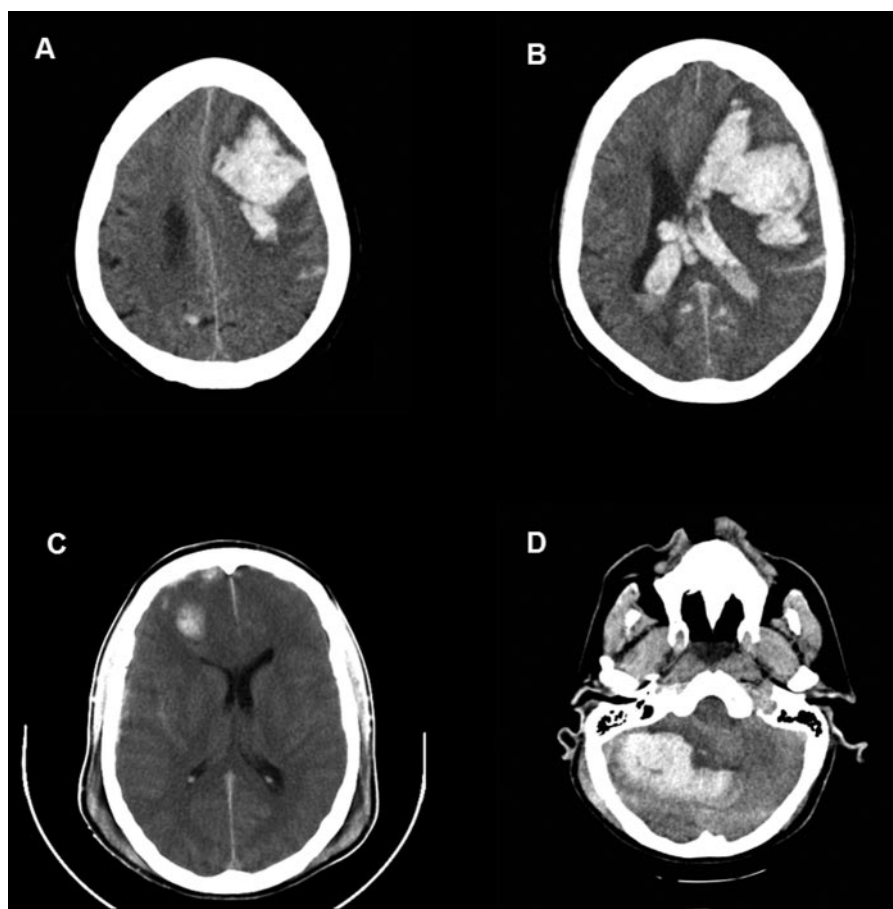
Computed tomographic scans showing intracerebral hemorrhage. A, Supratentorial lobar hematoma. B, Supratentorial hematoma with intraventricular extension. C, Traumatic intracerebral hemorrhage. D, Posterior fossa hemorrhage.
